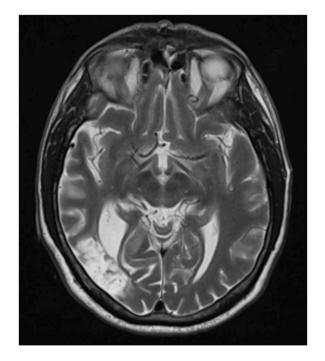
Brain MRI of the patient performed at two weeks. Axial view fluid-attenuated inversion recovery T2-weighted MR image shows hyperintense lesions in the right temporo-occipital area.
